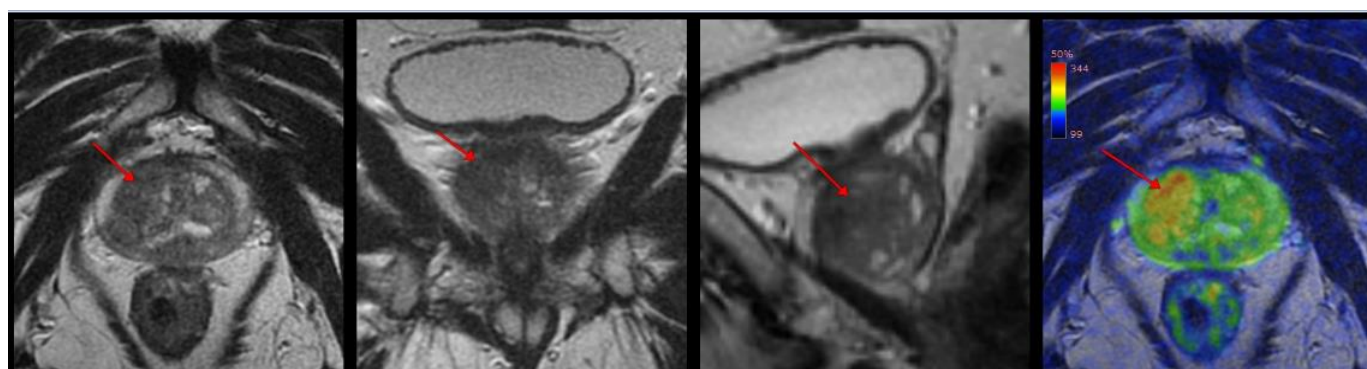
MRI of the transitional zone PCa
